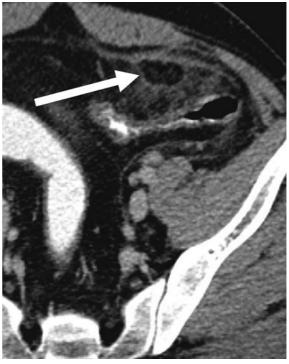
Epiploic appendagitis in an 89-year-old male, contrastenhanced CT. Oval, fatty mass adjacent to the anterior wall of the normal appearing sigmoid colon (*arrow*). Surrounding hyperdense rim and stranding of the pericolic fat. Central "dot" of increased attenuation
